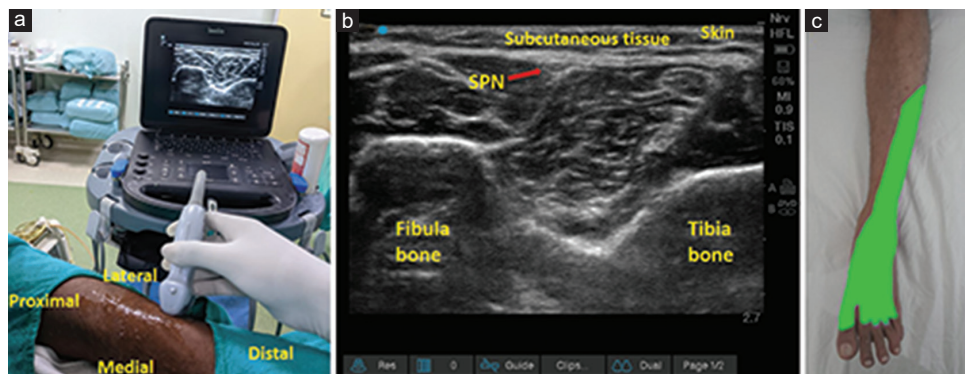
(a) Probe position at the middle and lower third of the anterolateral aspect of the leg for ultrasound-guided SPN block; (b) Sonoanatomy of SPN; The area of sensory innervation of SPN (green). SPN: Superficial peroneal nerve
